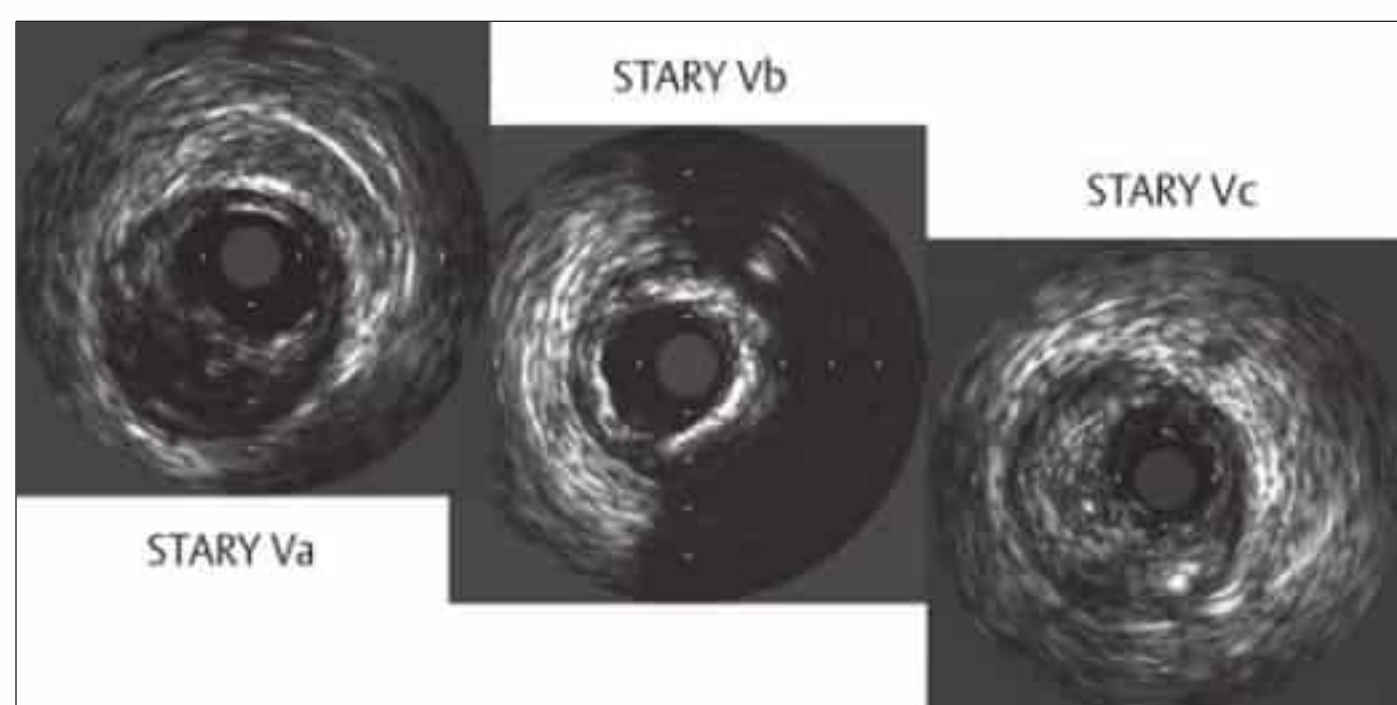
Intravascular ultrasound of Stary stages Va through Vc shows the formation of a fibroatheroma, fibrous cap, thinning of the cap at its margins, and a clear lumen (Va). Extensive calcifications with acoustic shadows and increased echogenicity are observed in stage Vb, and high-level echoes from eccentric plaque are seen in stage Vc of fibrotic plaque formation (after Erbel 1996¹³).
